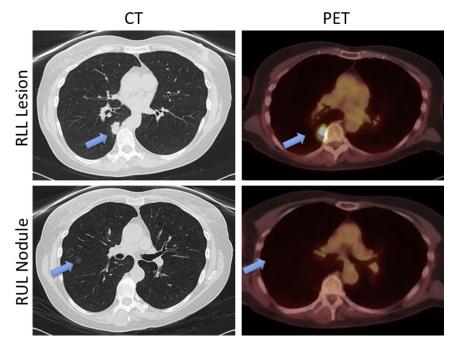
Preoperative CT scan demonstrating a 2.1-cm RLL nodule and a 6-mm RUL ground-glass opacity. Positron emission tomography scan of RLL nodule is positive (9.8 standardized uptake value), and RUL opacity is negative. *CT*, Computed tomography; *PET*, positron emission tomography; *RLL*, right lower lobe; *RUL*, right upper lobe.
